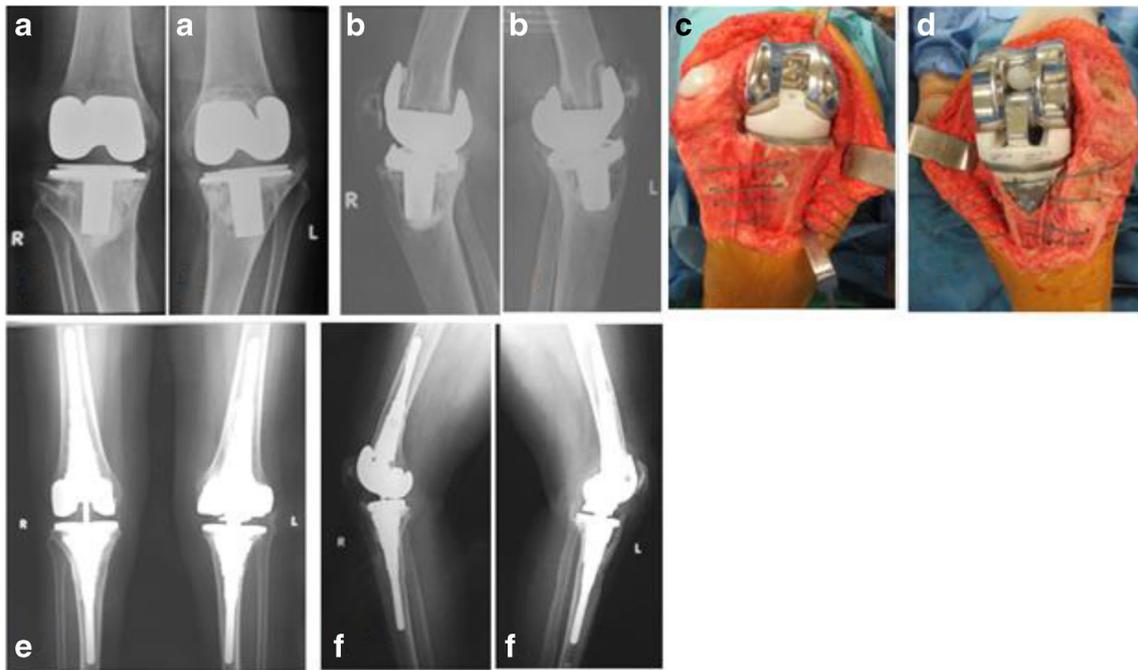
A&B) Aseptic loosening, C) Right knee: PFC® SIGMA® TC3 and reduction of Tibial tuberosity after ETTO with Ethibond, D) Left knee: S-ROM® Noiles™ and reduction of Tibial tuberosity after ETTO with Ethibond, E&F) AP radiographs after 4 months
